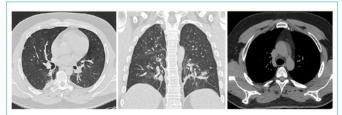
CT on admission: multiple, bilateral, patchy and confluent GGO with thickened septea and "crazy paving" pattern in association with segmentary consolidations in lower lobes. Follow-up CT examinations, 9 days later shows significant reduction in extension and density of GGO and consolidation areas too. Note the absence of thymic gland.
